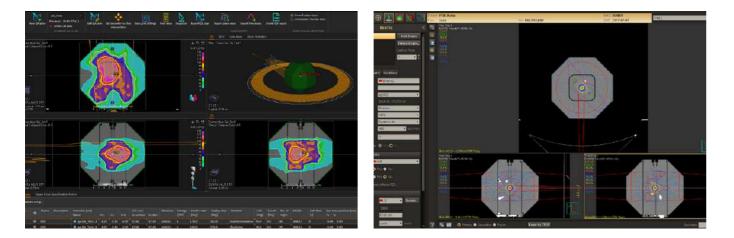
Treatment plan calculated on CT dataset of Patient QA detector insert.
